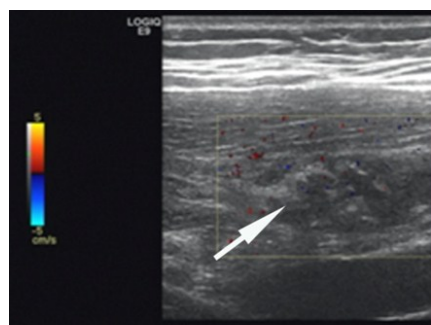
Ultrasound examination showed a asymmetrical low echo area in the right buttock muscle, and no obvious abnormal blood flow signals inside and around the lesion.
